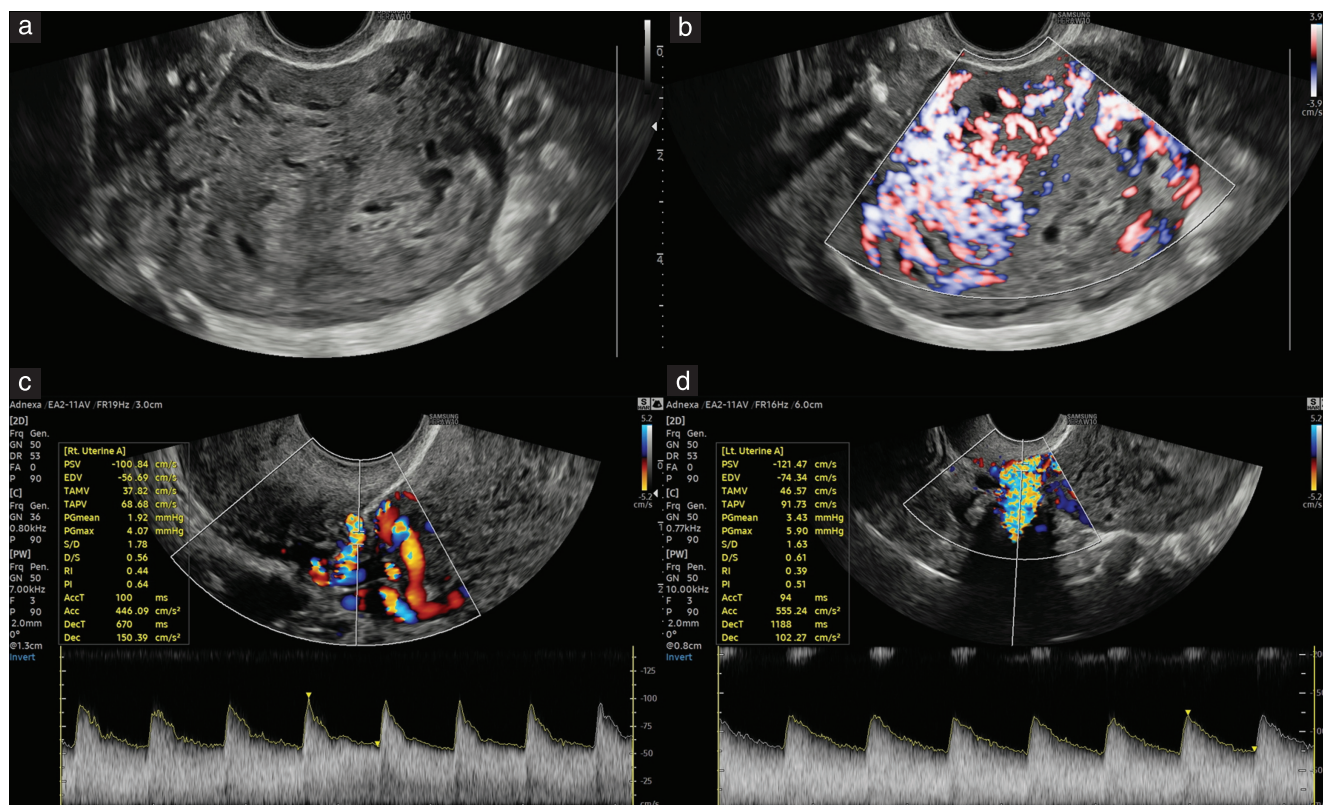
Transvaginal ultrasound imaging of gestational choriocarcinoma. (a) Grayscale image of uterus (transverse view). (b) Power Doppler interrogation of nodule in transverse view. (c,d) Spectral Doppler images and waveforms showing right (c) and left (d) uterine arteries.
